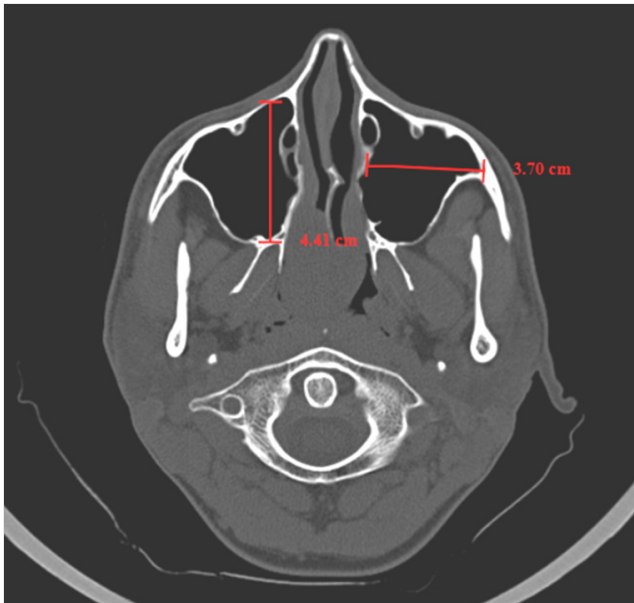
Axial computed tomography (CT) scan showing the measurement of the anteroposterior (AP) and mediolateral (ML) dimensions
